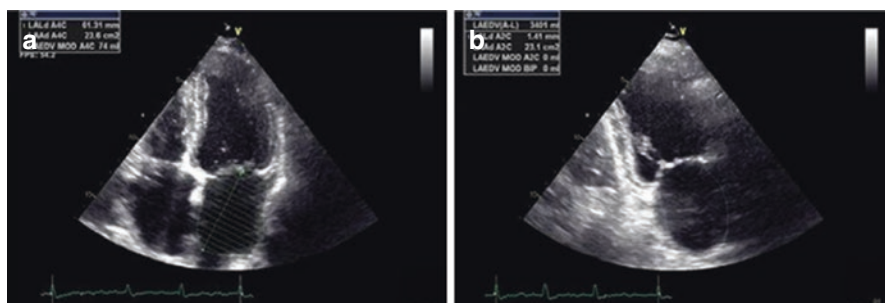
Measuring left atrium size using biplane method, by measuring left atrium volume in apical 4 and 2 chamber views
